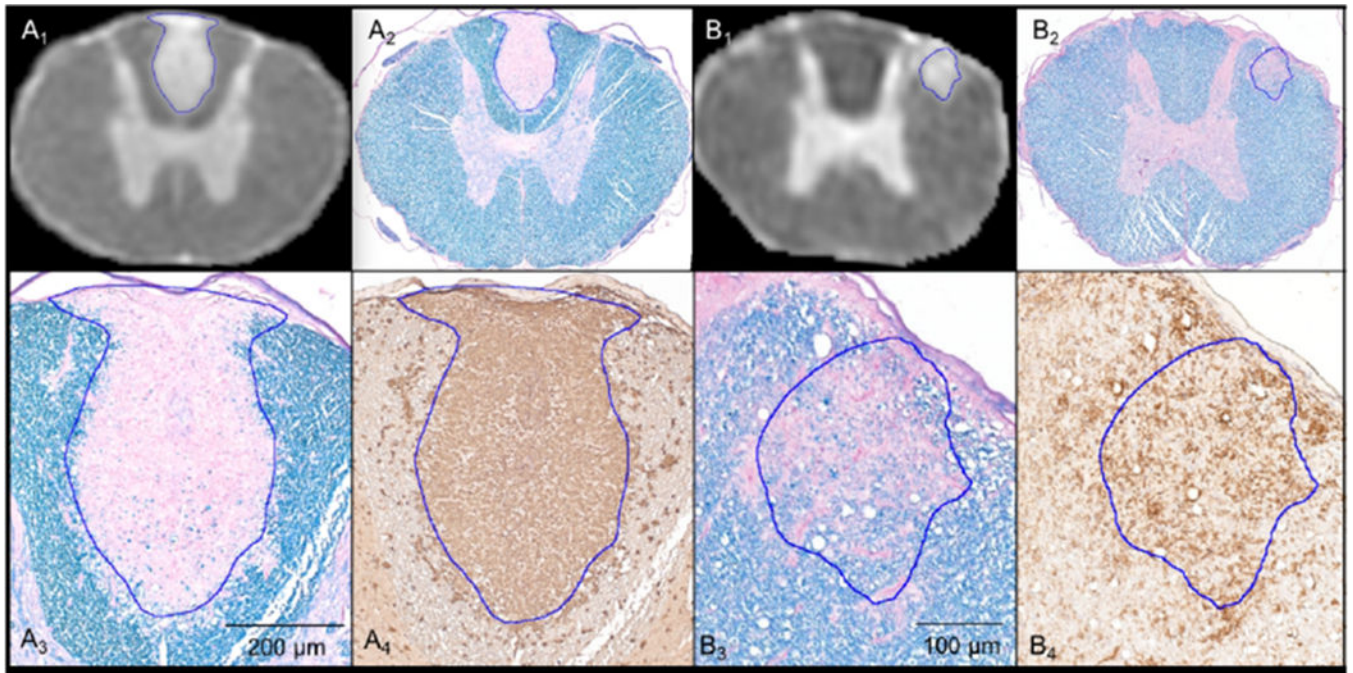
MRI scans (A₁ and B₁) coregistered to the corresponding LFB-PAS images (A₂ and B₂) for defining the lesion contour ROI (blue lines). Magnified views of the lesions for LFB-PAS (A₃ and B₃) and Iba-1 (A₄ and B₄). A₃ and A₄ show complete myelin loss and uniform intensity of inflammatory cells throughout the entire lesion. B₃ and B₄ show a partially demyelinated lesion with moderate inflammation.
